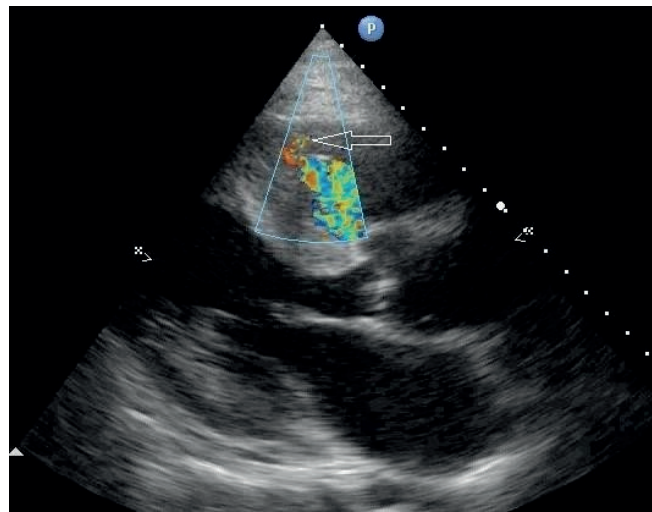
Echocardiography. Parasternal long-axis view. Colour Doppler echocardiography of turbulent flow in the right ventricle
